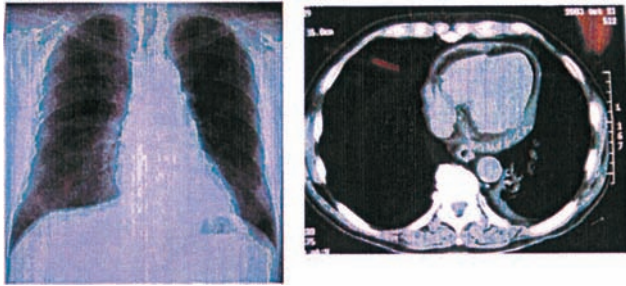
Slight radiation pneumonitis can be seen in the lung field surrounding the lower part of the mediastinum, and CT scan reveals a small amount of pericardial effusions and pleural effusions on the left side.
